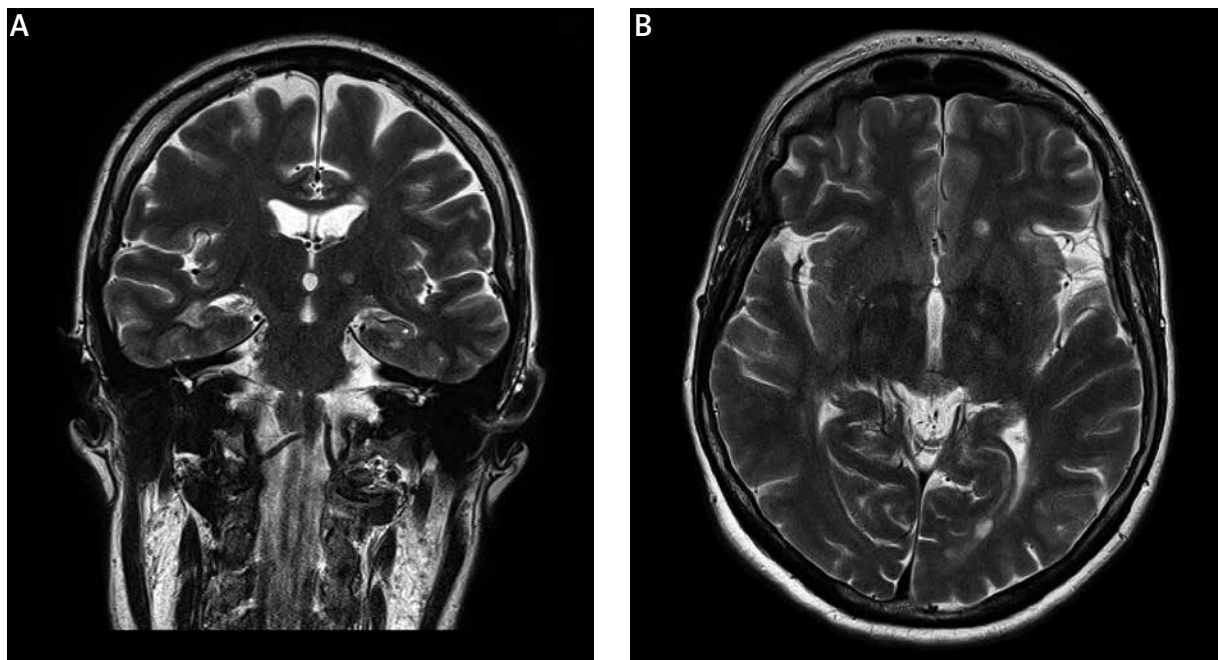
Case 6. A) Coronal and B) axial MRI T2 images show demyelinating lesions in both thalami, periventricular and cortico-subcortical area.
